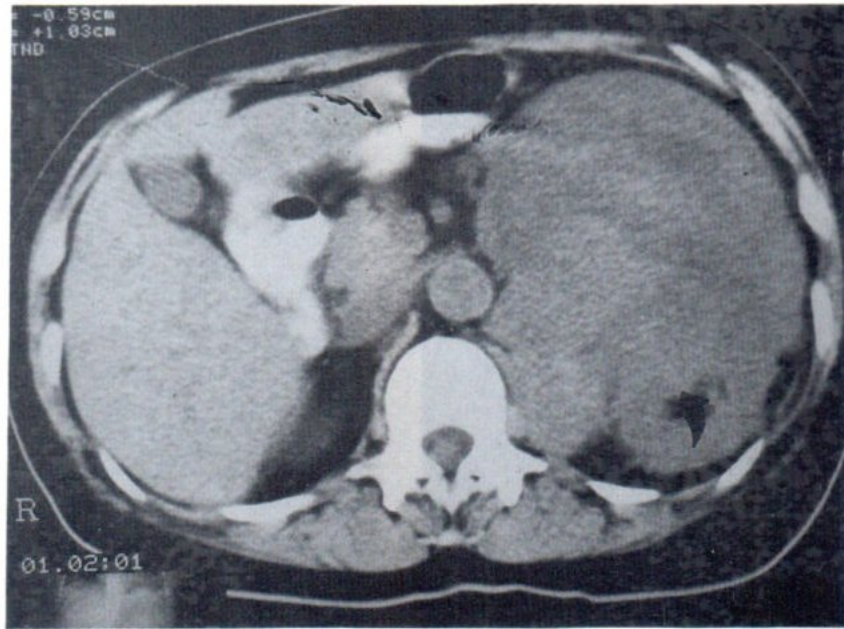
Non i.v. contrast CT scan of the mass showed no calcification.
